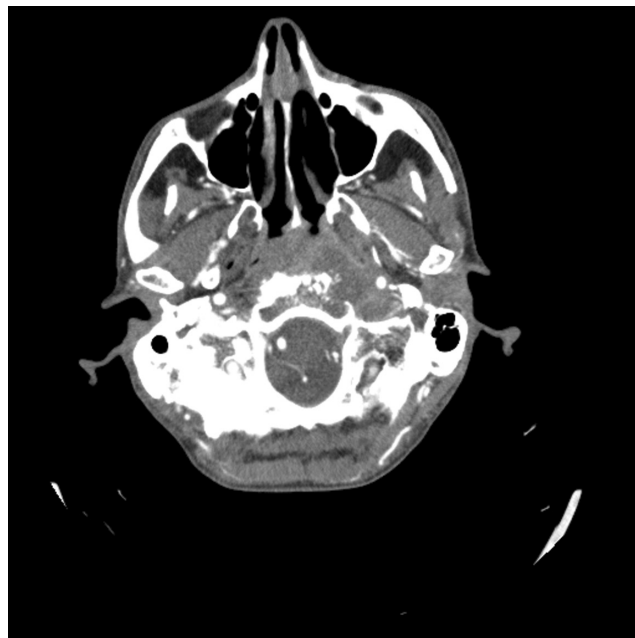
Brain and neck CT scan with contrast revealed a hypodense mass-like lesion with mild enhancement in the left parapharyngeal
